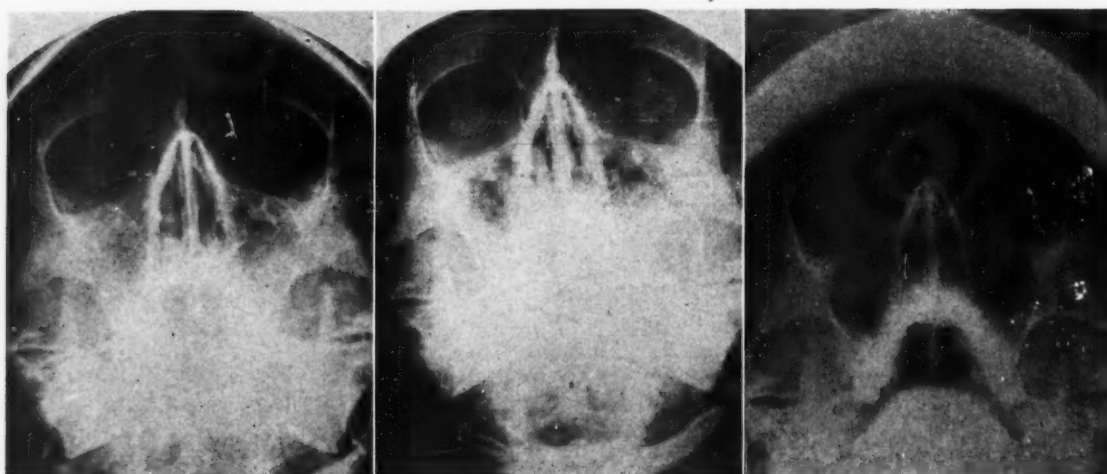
Sinus x-rays after one week of control therapy (left), after one week of penicillin aerosol with negative pressure (center) and one month later (right) showing progressive clearing.
